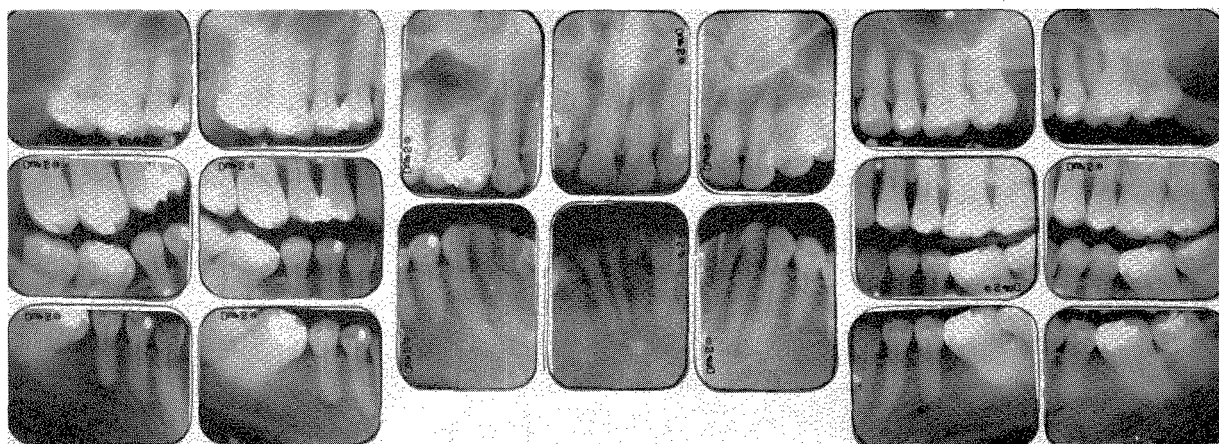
May, 1961, roentgenograms of the patient shown in Figs. 30 and 31.
